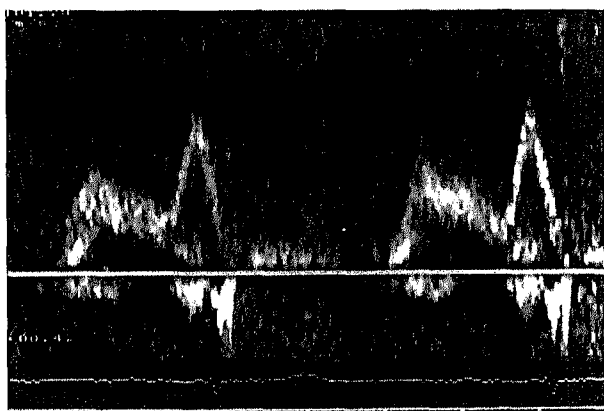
Changes in Doppler diastolic filling pattern after training. Left, Before exercise training, a diastolic filling pattern of abnormal relaxation is evident, with a reduced peak early filling velocity, a prolonged deceleration time of peak early filling velocity, a greater peak atrial filling velocity, and a reduced E/A ratio (0.7). The isovolumic relaxation time, not shown here, was also prolonged. Right, After exercise training, there was a radical change in diastolic filling pattern, with an increased peak early filling velocity with shorter deceleration time, a reduced peak atrial filling velocity, and a greater E/A ratio (1.44).
